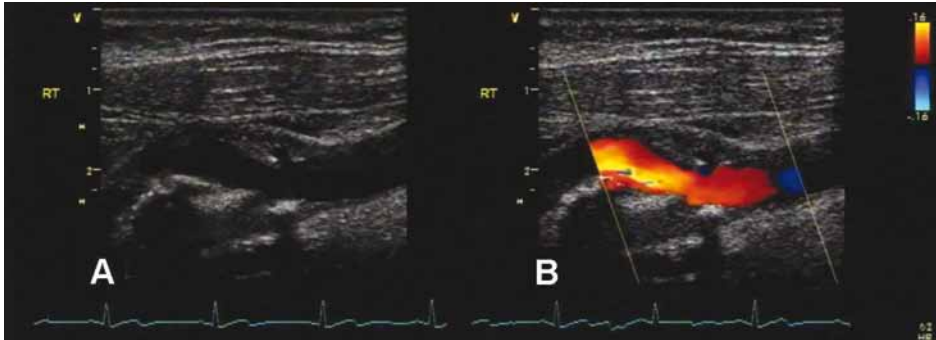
B-mode (A) and duplex (B) ultrasound images of the common carotid artery. An ulcerated atherosclerotic plaque can be observed at the origin of the internal carotid artery. The addition of color Doppler shows a clear improvement in the identification of the plaque border.
